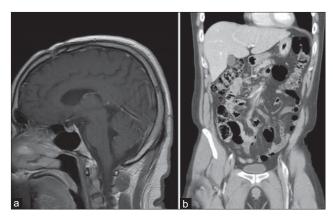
(a) A contrast-enhanced brain magnetic resonance imaging revealed the pineal region mass significantly decreased in size with no obstructive hydrocephalus. (b) The contrast-enhanced coronal abdominal computed tomography image shows no residual mass lesion in the abdominal cavity after radiotherapy and surgical resection
